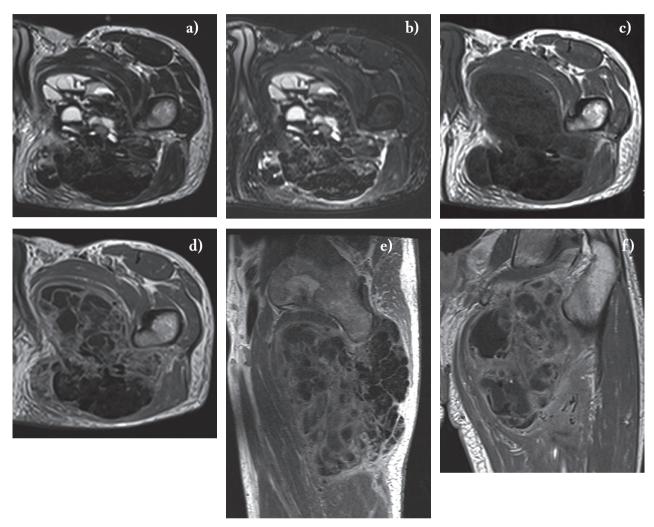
On MRI axial T2w (a) and fat-suppressed T2w (b) sequences the lesion present low intensity and bright nodular areas, with cystic components and fluid-fluid levels ("sedimentation sign"). On T1w sequences (c) lesion shows inhomogeneous diffuse low signal intensity. After CE injection, T1w axial, coronal and sagittal images show (d, e and f) fibrous septa surrounding cystic and calcified areas enhanced, producing a "web" or "cobblestone" pattern.
